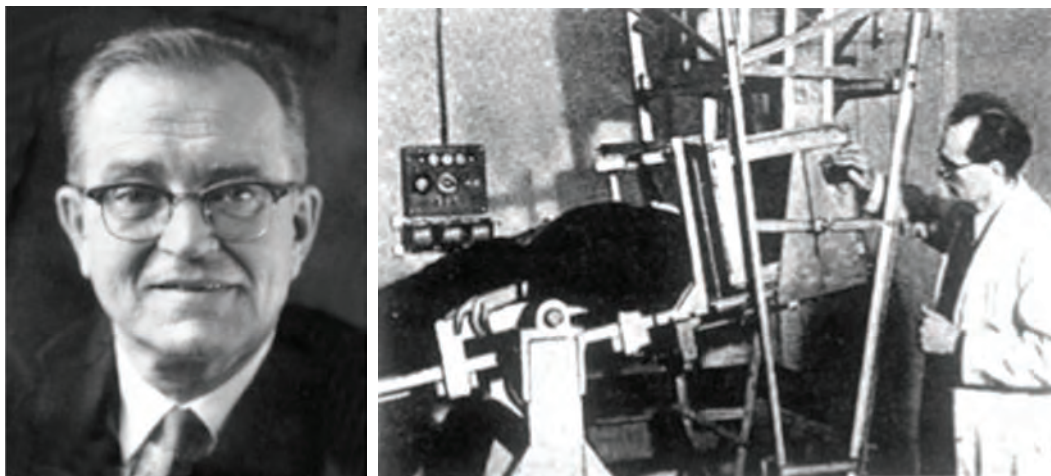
In the 1940s, Dr. Karl Dussik (1908–1968) made one of the earliest applications of ultrasound to medical diagnosis when he used two transducers positioned on opposite sides of the head to measure ultrasound transmission profiles. He discovered that tumors and other intracranial lesions could be detected by this technique.
